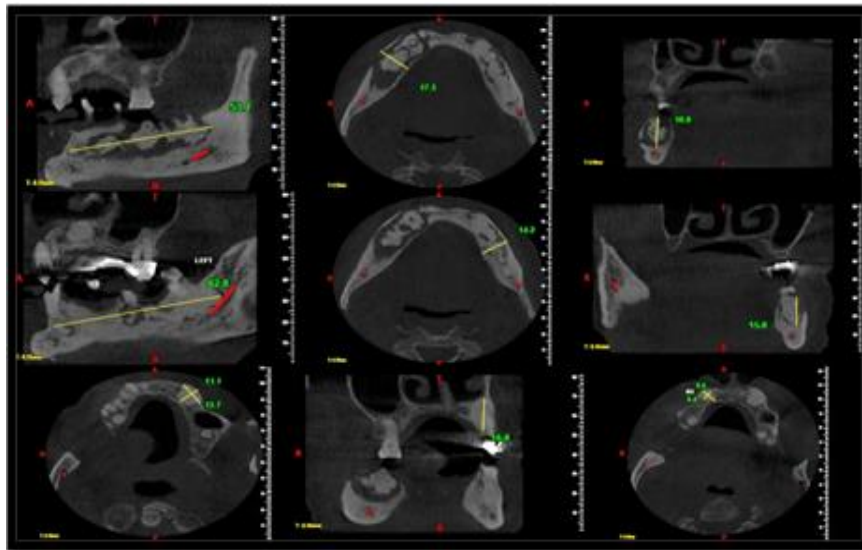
Cone-Beam Computed Tomography scan showing multifocal mixed radiolucent-radiopaque lesions
